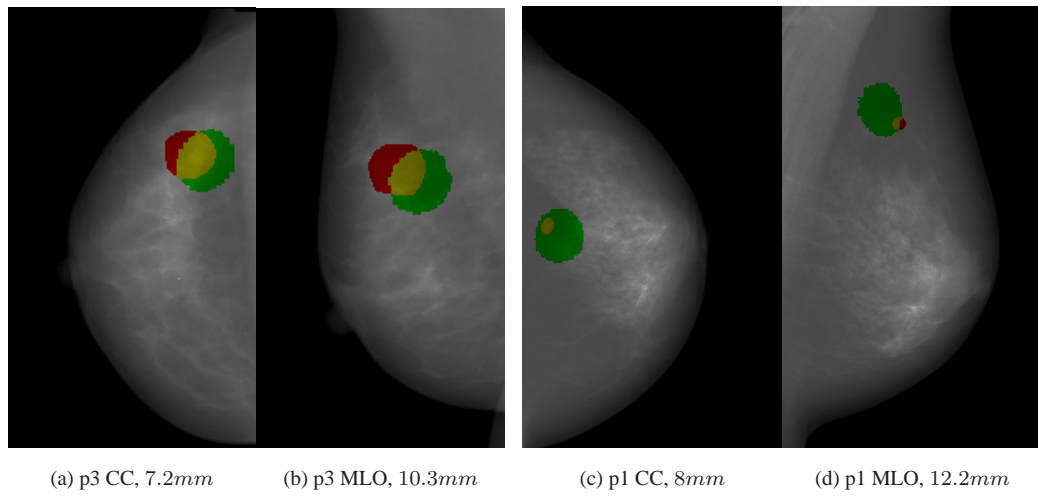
Registration results for two patients with identified lesions. The X-ray annotation is shown in red and the projection of the MR annotation in green; their overlap is yellow.
